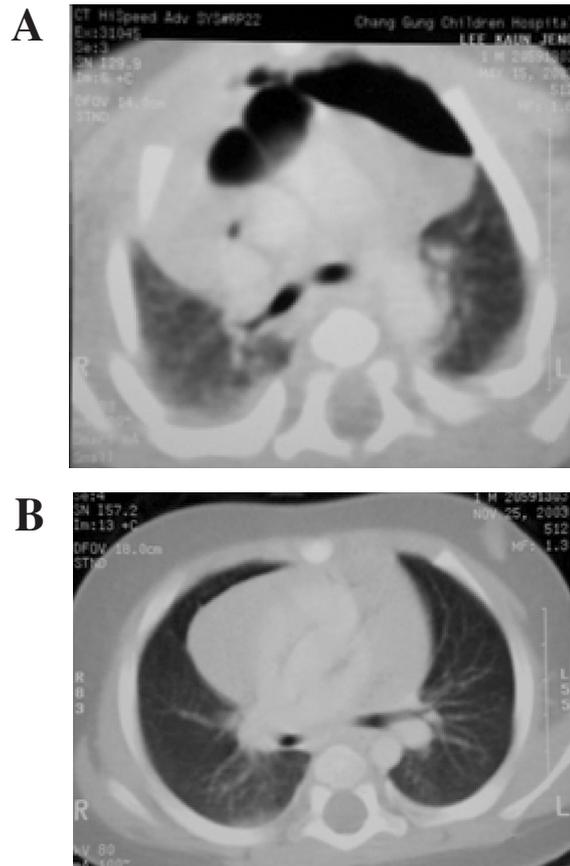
(A) Computed tomography (CT) of patient 7 at 3 days old shows abnormal air-containing structure with septum in the anterior aspect of the thymus. (B) Disappearance of pre-existing lung lesion 7 months later.
